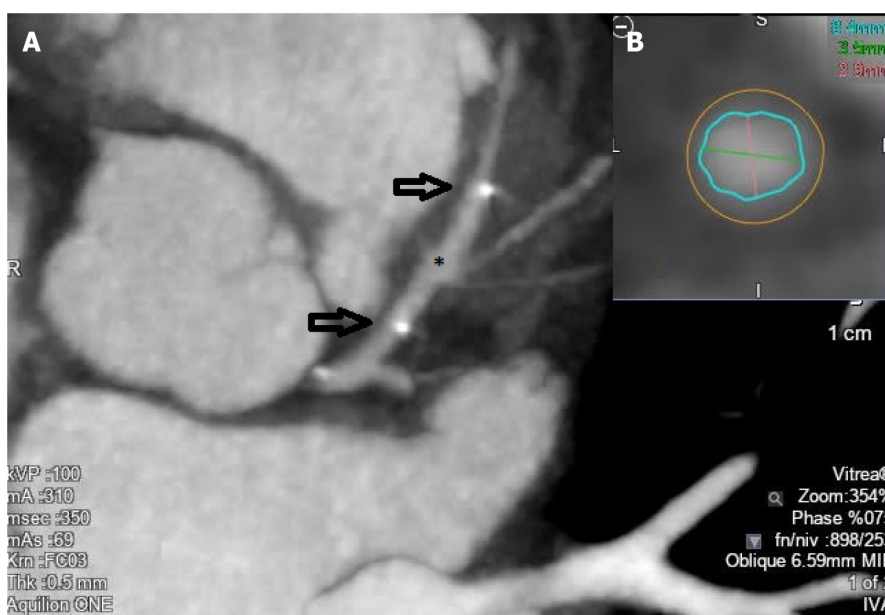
Coronary computed tomography angiography image of a bioresorbable stent (asterisk) implanted at the level of the proximal left anterior descending artery (A) (the two arrows represent the two radiopaque stent markers), and cross sectional cut allowing for lumen measurements (B).
